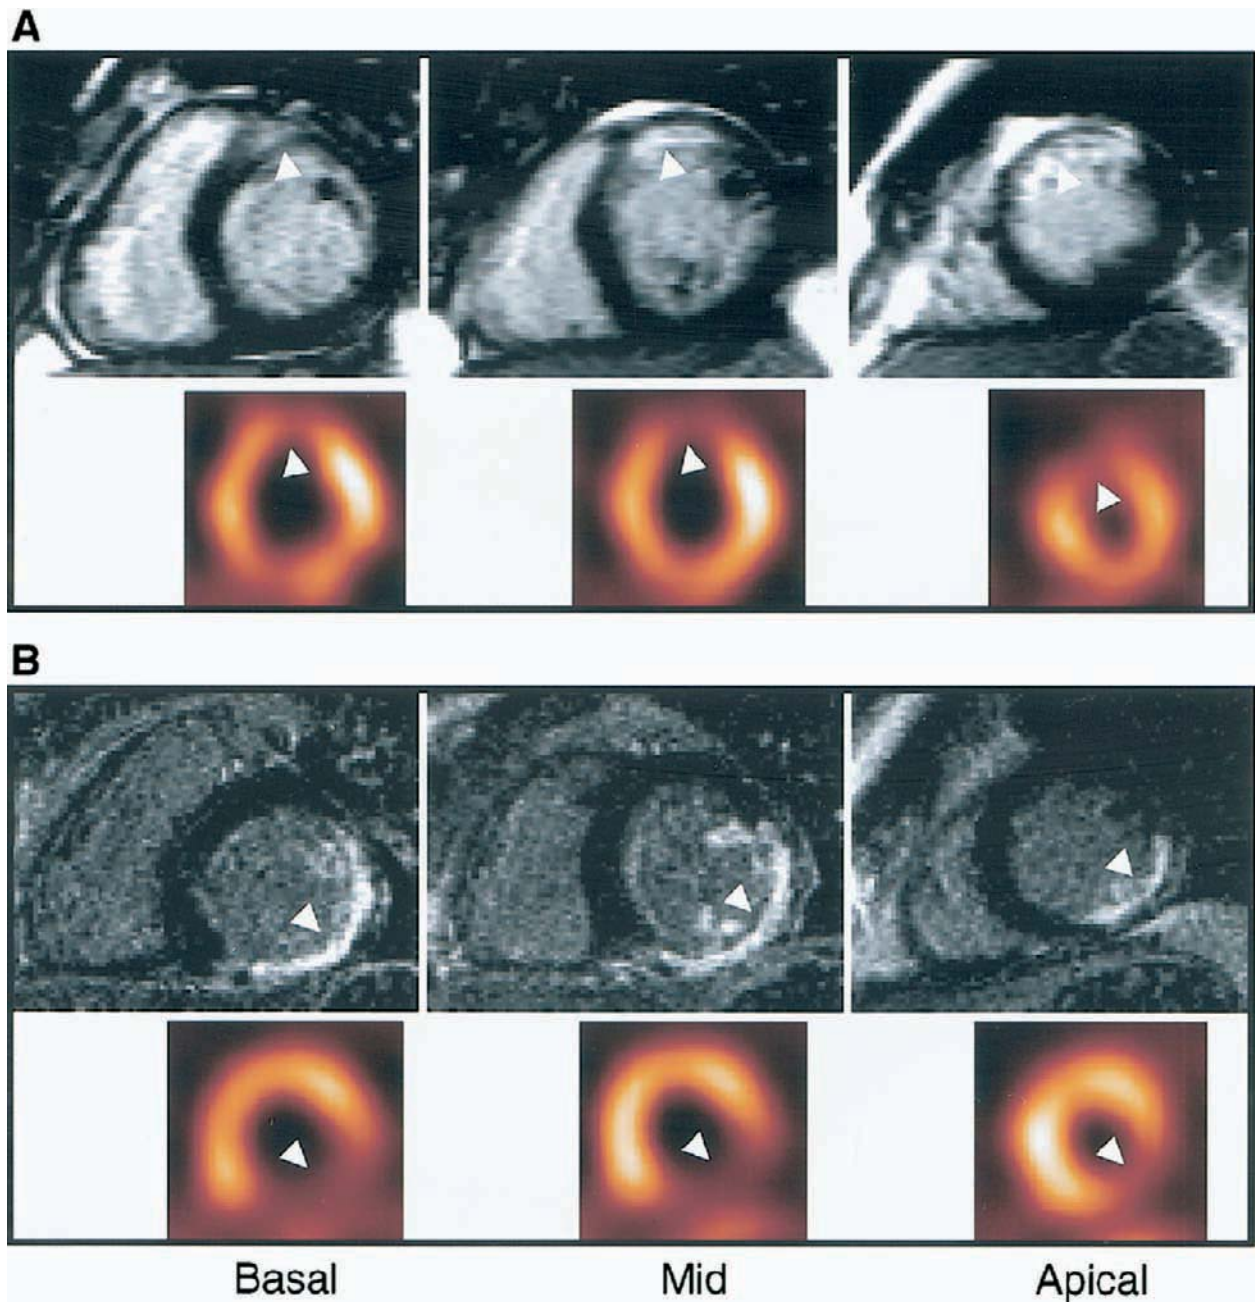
Images demonstrate delayed-enhancement MRI of AMI in comparison to SPECT. A, Subendocardial delayed enhancement in anterior and anteroseptal walls (transmural extent, 25%-75%) by use of MRI (*upper row, arrowheads*) and corresponding perfusion defect by SPECT (*lower row, arrowheads*). B, Transmurality delayed enhancement in inferior wall (transmural extent, 75%-100%) and subendocardial enhancement extending to lateral wall (transmural extent, 25%-75%) by use of MRI (*upper row, arrowheads*) with corresponding perfusion defects on SPECT (*lower row, arrowheads*). Both patients were imaged 1 week after AMI. (Reproduced with permission from Ibrahim et al.⁵³)
